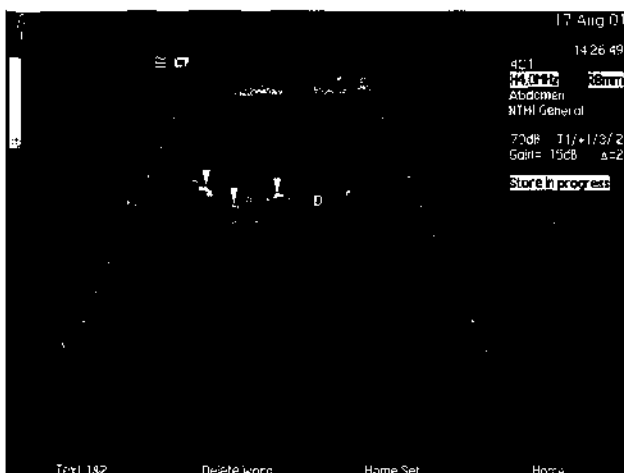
Chronic pancreatitis. Ultrasound is not sensitive to the changes of chronic pancreatitis, but when there is calcification, within the duct in this case (arrowheads), the changes are easily demonstrated. D, Pancreatic duct.
